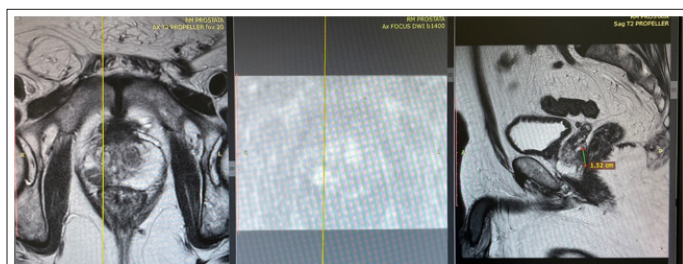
mpMRI Sequences (In Order from Left to Right: Axial T2, DWI and Sagittal T2)
